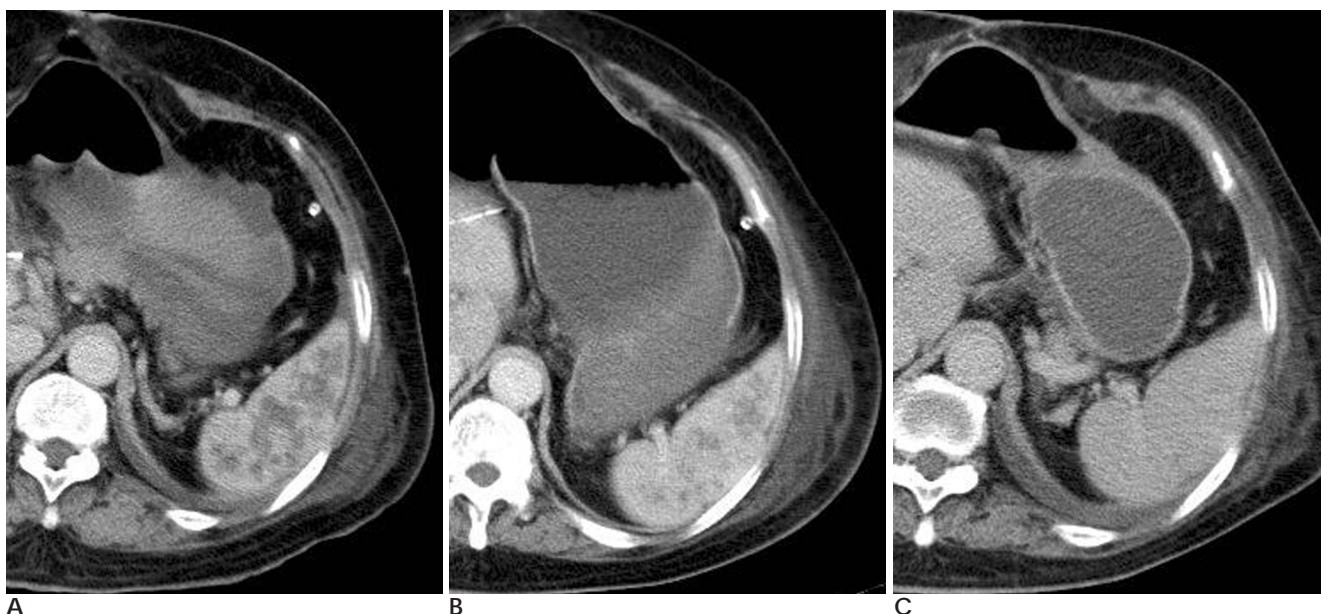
A. Delayed phase CT scan taken on 6th days after embolization shows a geographic low density lesion in the central portion of the spleen.
